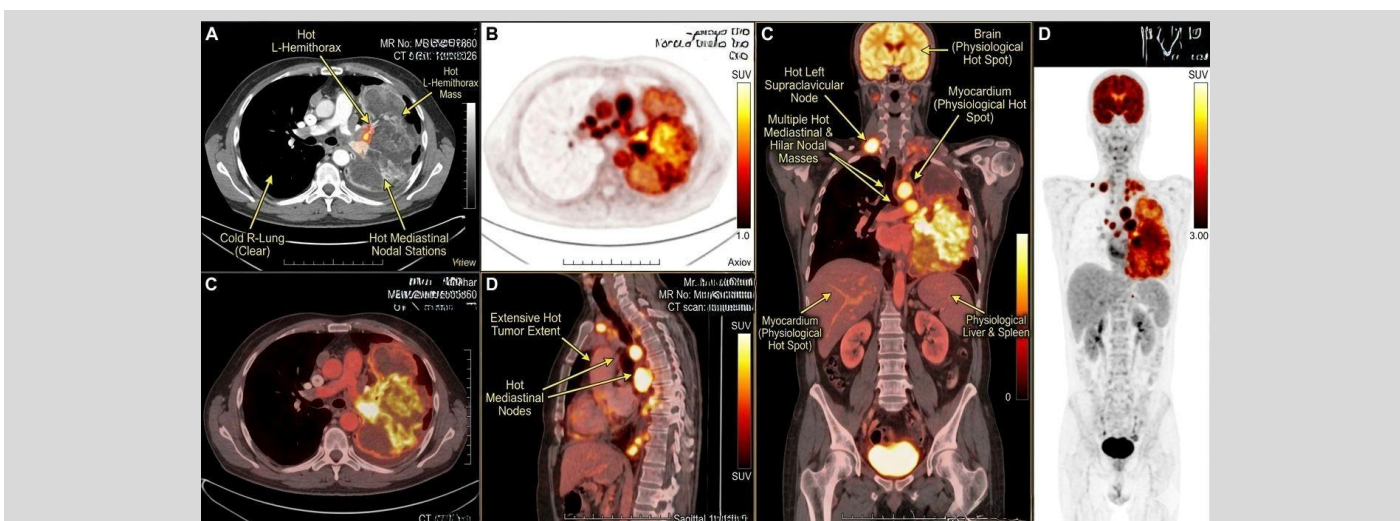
18F-FDG PET/CT demonstrates an intensely hypermetabolic, bulky mass occupying the entire left hemithorax (Panels A, C, MIP), representing the dominant primary malignancy with high glycolytic activity, in stark contrast to the metabolically inert (“cold”) right lung (Panel A), which remains uninvolved. There is extensive contiguous and discontinuous nodal dissemination, with multiple FDG-avid mediastinal and hilar nodal stations (Panels A, C, sagittal D) forming conglomerate hypermetabolic nodal masses, indicating advanced intrathoracic lymphatic spread. A markedly avid left supraclavicular lymph node (coronal view) signifies extrathoracic nodal metastasis and serves as a critical staging determinant. Multiplanar reconstructions, including sagittal and coronal views, delineate the craniocaudal and anteroposterior extent of disease, confirming near-complete occupation of the left thoracic cavity. Physiological tracer uptake is appropriately noted in the brain, myocardium, liver, and spleen, preventing interpretative confounding. The whole-body maximum intensity projection consolidates these findings, depicting a dominant unilateral thoracic disease burden with extensive nodal involvement and no significant distant visceral hypermetabolic foci beyond expected physiological distribution.
